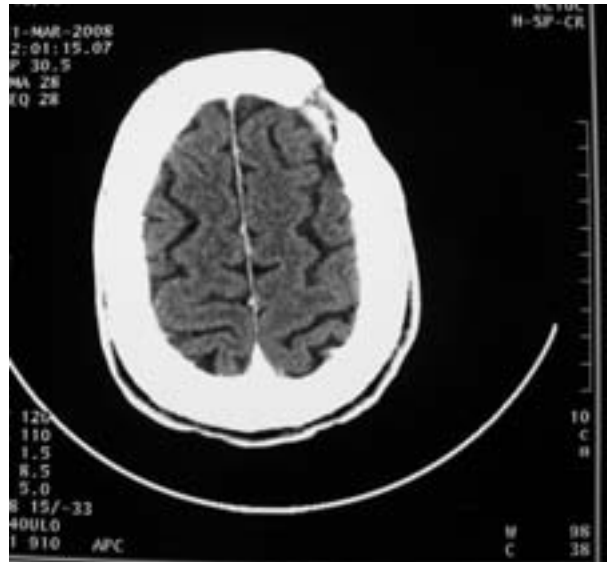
Computed tomography scan of the head performed at the end of antibiotic therapy showing the removal of the epidural empyema.
